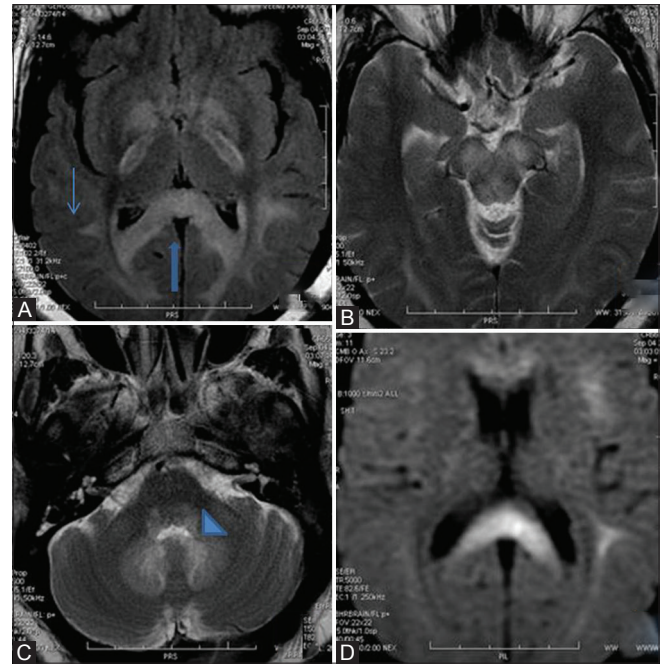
(A-D): Initial Magnetic resonance imaging (Brain) of case 2, showing symmetric areas of hyper intensity involving the splenium of the corpus callosum (arrow) on (A) Axial DWI with restricted diffusion (value of  $0.6 \times 10^{-3} \text{ mm}^2/\text{s}$ ) on ADC map (B), (C) axial T2-weighted images, signal change in corpus callosum (D) Axial DWI no signal change in cerebellum and pons
